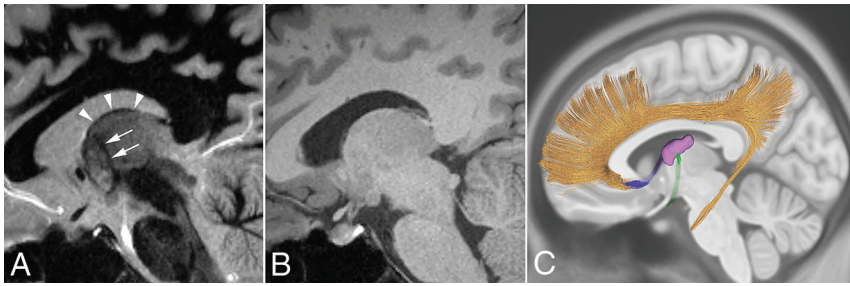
Sagittal 3T FGATIR MR imaging (A) compared with MPRAGE (B) in the same patient. The FGATIR more clearly highlights the course of the mammillothalamic tract (arrow) seen as a dark band extending from the mammillary body, through the thalamus, and terminating at the base of the anterior ANT (outlined by arrowheads). Sagittal view of the main connections of the ANT (purple region) (C). The mammillothalamic tract (green) connects the mammillary body to the ANT. Tracts (blue) then connect the ANT (through the stria terminalis) with the anterior cingulate and cingulate bundle (orange).
